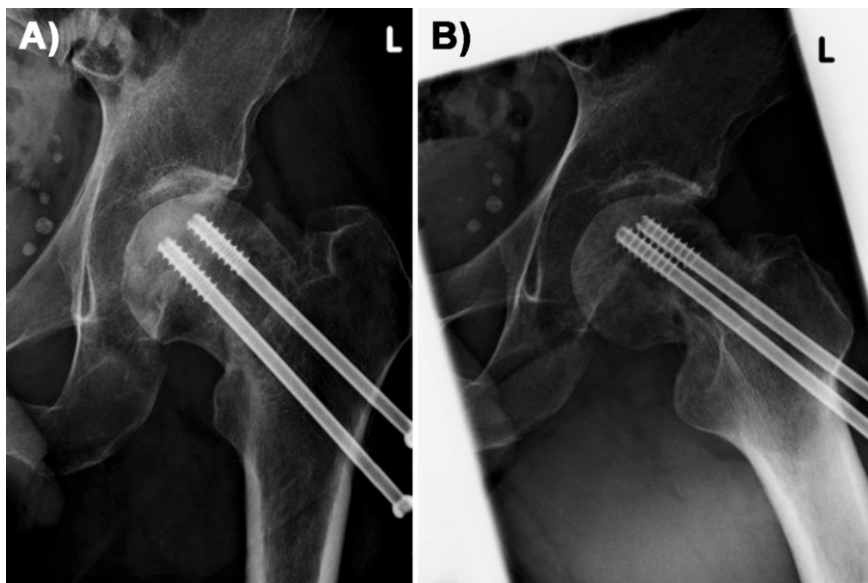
Anteroposterior (A) and lateral (B) radiographs of the left femur 4 months after initial surgery (2 hip-screws) show an impaction of the femoral head into the femoral neck.
